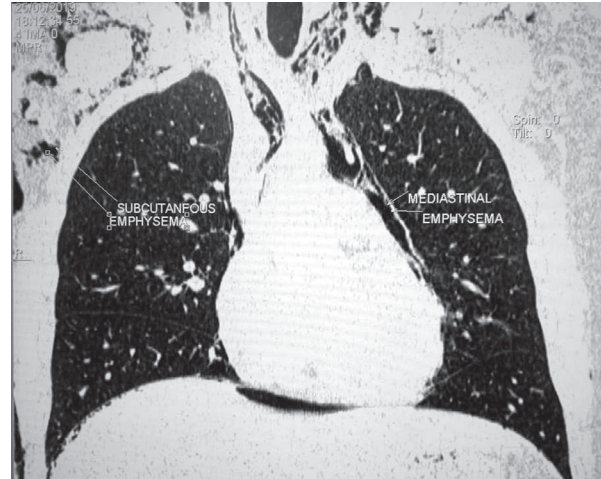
Non-contrast computed tomography chest showing subcutaneous emphysema and pneumomediastinum
